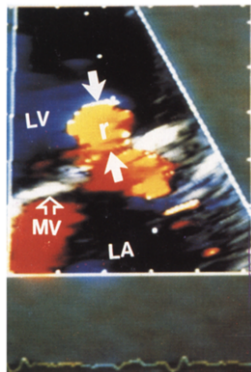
Doppler color two-dimensional recording of a proximal accelerating flow region. The Nyquist velocity for the flow away from the transducer was 29 cm/s as shown on the color scale display at left and the radius of the proximal isovelocity layer (r) was 1.2 cm (the measurement is labeled by two solid arrows) in this case. The distance between 2 dots is 1 cm. In this patient, the downstream regurgitant jet was directed eccentrically to the wall. The wall jet was small on the color Doppler flow mapping. LA = left atrium; LV = left ventricle; MV = mitral valve leaflet.
